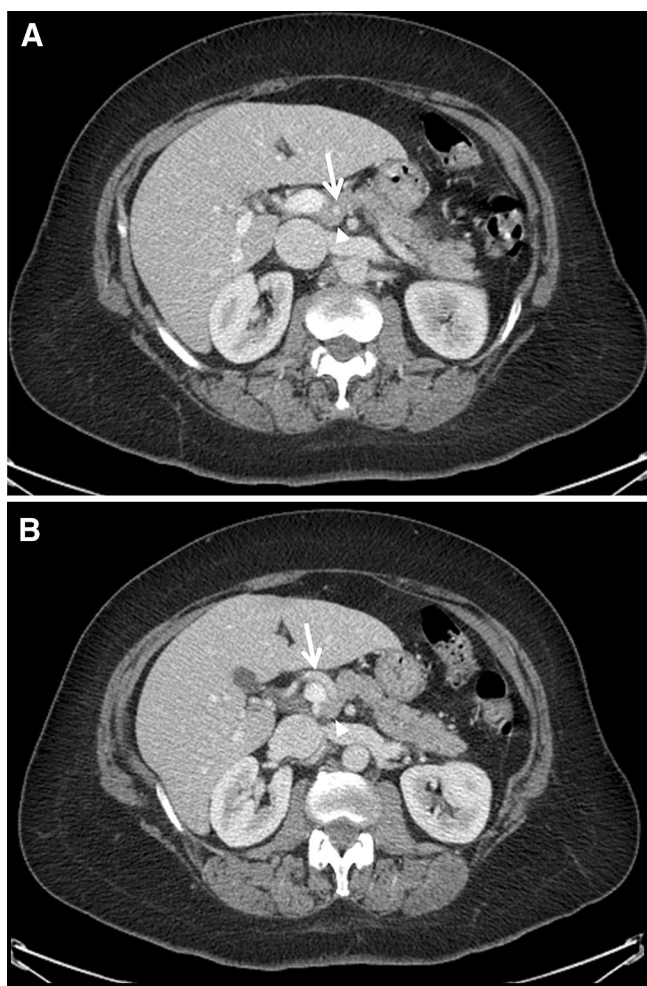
Intraparenchymal course of the common hepatic artery in a 67-year-old woman with infrasplenic circumportal pancreas and anteportal duct. Post-contrast CT images cranial to caudal (A–B). The pancreatic parenchyma (*arrow-head*) surrounds the common hepatic artery (*white arrow*).
